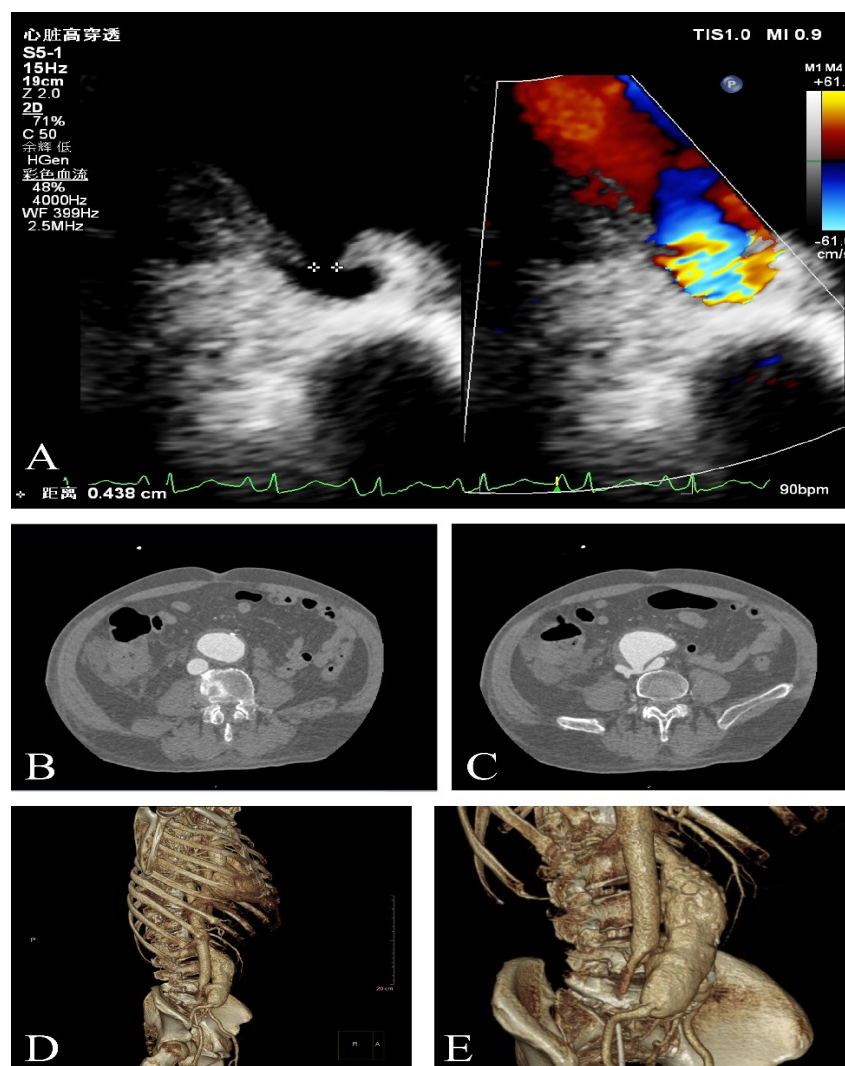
Ultrasound images and CT of an AAA and AVF located between right common iliac artery aneurysm and IVC. Imaging was captured within one hour of admission. Fig. 1A was sonograms showing an AAA and AVF between right common iliac artery aneurysm and IVC. AVF (thick arrows) between right common iliac artery aneurysm and IVC is clearly visible. Fig. 1B and 1C were axial images from enhanced CT scans. Continuity between the right common iliac artery aneurysm and IVC represents AVF (thin arrow). Figure 1D and 1E were three-dimensional volume-rendered images of the AAA and AVF (red arrows). The figure here is original for this paper.
